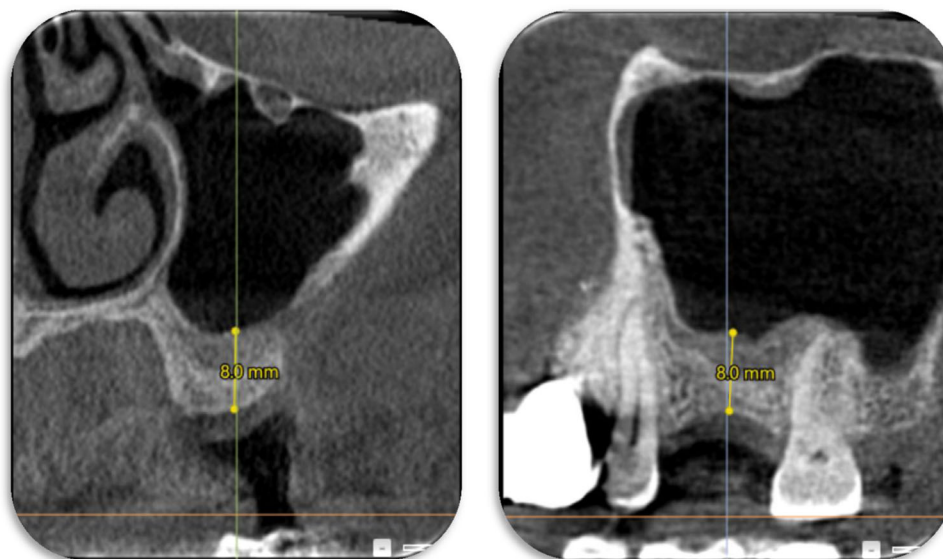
Six months post sinus augmentation CBCT radiographically suggests an approximate gain of 4.5 mm of vertical bone height over preoperative CBCT.
